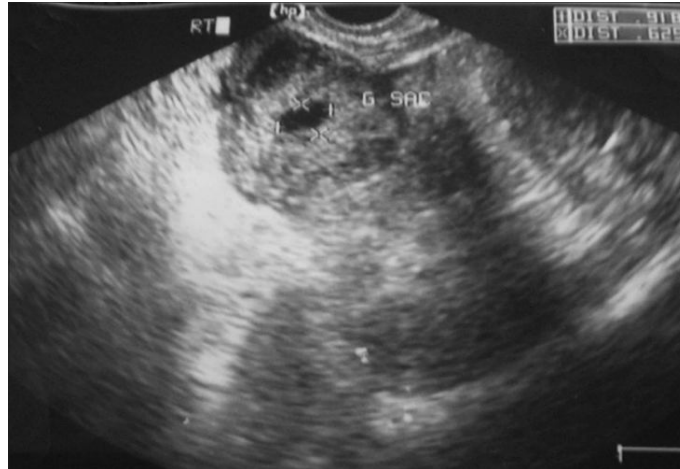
TVS ultrasonography showing ectopic gestation
